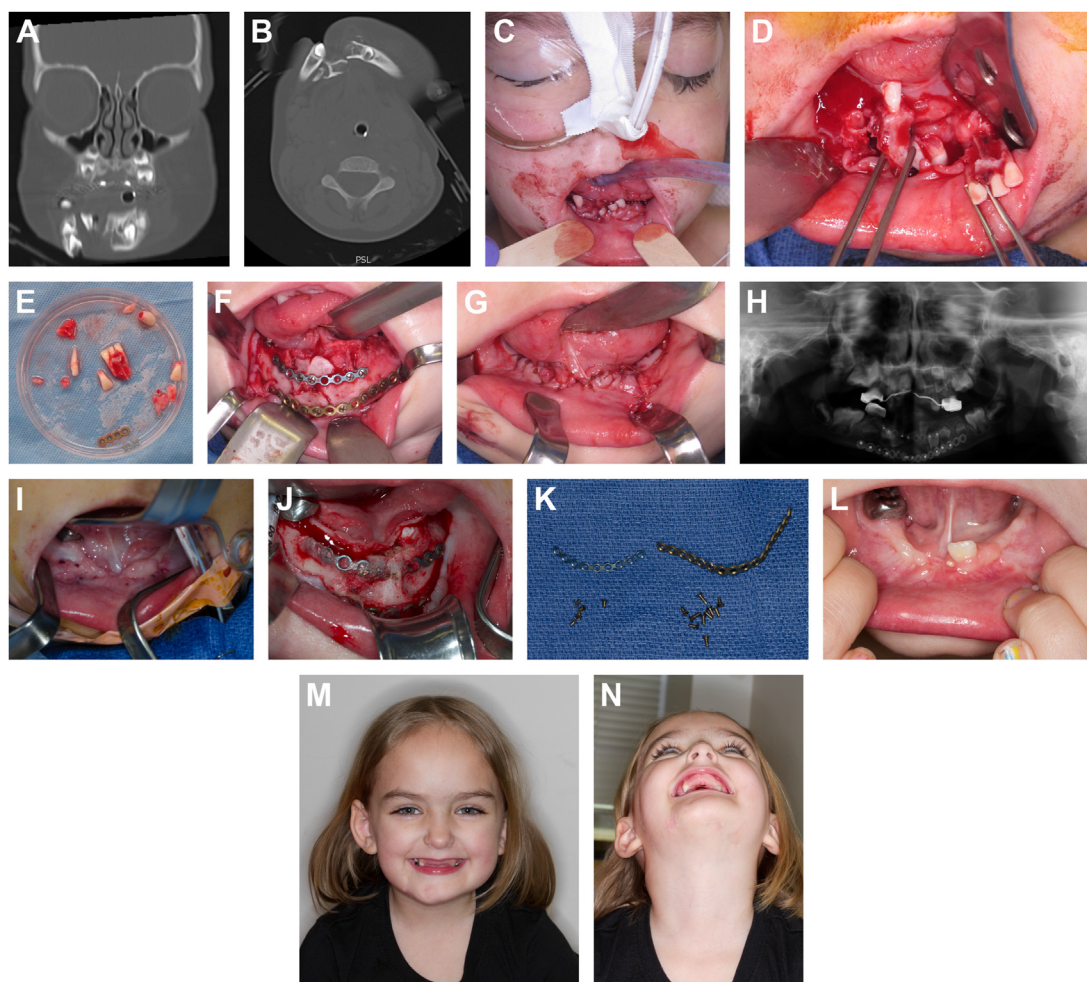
Case of a 6-year-old patient who sustained a comminuted mandible fracture from an unrestrained motor vehicle accident. CT (A) coronal and (B) axial views demonstrating complex anterior mandible fracture with developing permanent dentition. (C) Clinical examination and (D, E) intraoperative findings significant for mobile dentition and multiple unsupported bone fragments. (F, G) Two load-sharing titanium miniplates used with monocortical screws to fixate the free-floating bone and provide rigid stabilization of the mandible. (H) Postoperative panoramic radiograph. Patient returned to the operating room 7 weeks later for the removal of the titanium hardware. (I, J) Exposure of the plates and screws was notable for bony overgrowth during the interval period. (K) Explanted hardware. (L–N) Three-month postoperative follow-up with good chin point symmetry and successful emergence of the permanent lateral incisor that was preserved in the zone of injury.
